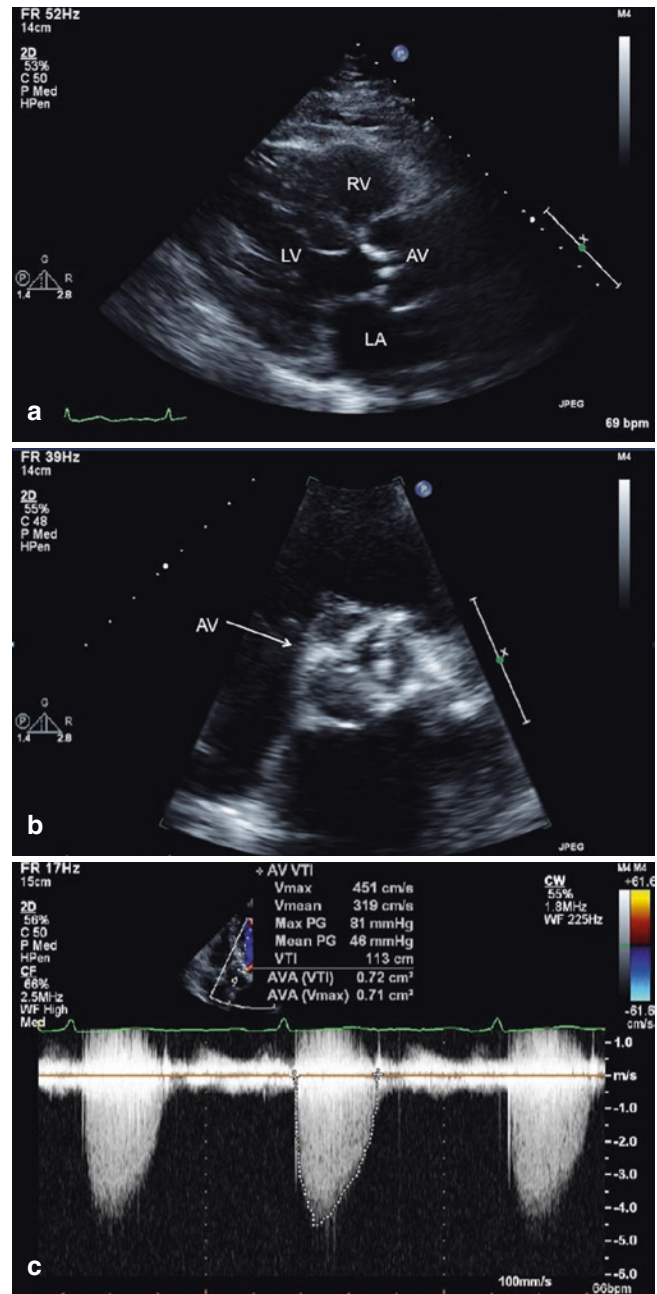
Echocardiographic appearance of severe aortic stenosis. Panel A is a parasternal long-axis view showing a severely thickening and severely restricted aortic valve. Panel B is a parasternal short-axis view at the level of the aortic valve during systole showing a severely calcified and restricted trileaflet aortic valve. Panel C is a continuous wave spectral Doppler assessment of flow across a severely stenotic aortic valve with a peak velocity 4.5 m/s and mean gradient 46 mmHg. The aortic valve area can be calculated by echocardiography (utilizing the pulse wave Doppler velocity in the left ventricular outflow tract, left ventricular outflow tract diameter, and the continuity equation). This calculated aortic valve area is well validated to correlate with other measurements of aortic valve area. In the case shown here, the echocardiographically derived calculated aortic valve area is $\sim 0.7 \text{ cm}^2$, consistent with severe aortic stenosis. AV, aortic valve; AVA = aortic valve area; LA, left atrium; LV, left ventricle; RV, right ventricle; Vmax, peak velocity
